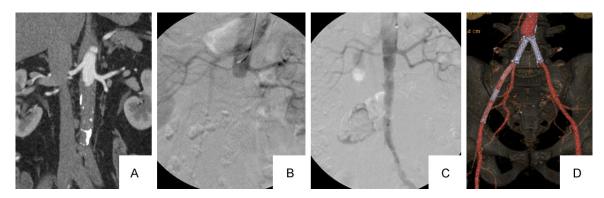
Case 5. A: CT demonstrating juxtarenal aortic occlusion, abdominal aortic calcification, and intraluminal thrombosis; B: Angiography indicating juxtarenal aortic occlusion; C: Complete lysis of the thrombus in the abdominal aortic artery after thrombolysis; D: CT image at 12 months after treatment.
